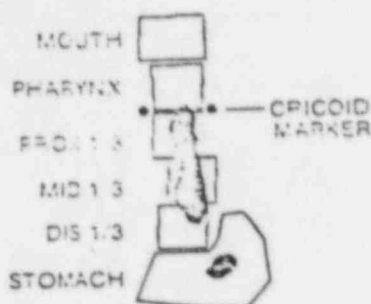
Single scintigraphic image taken from normal swallowing sequence demonstrating areas of interest.
